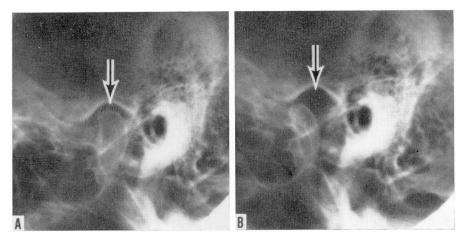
A, Roentgenogram of a normal temporomandibular joint, closed position. Arrow points to top of fossa. B, Roentgenogram of a normal temporomandibular joint, open position. Note difference in condylar position. Arrow points to top of fossa.
